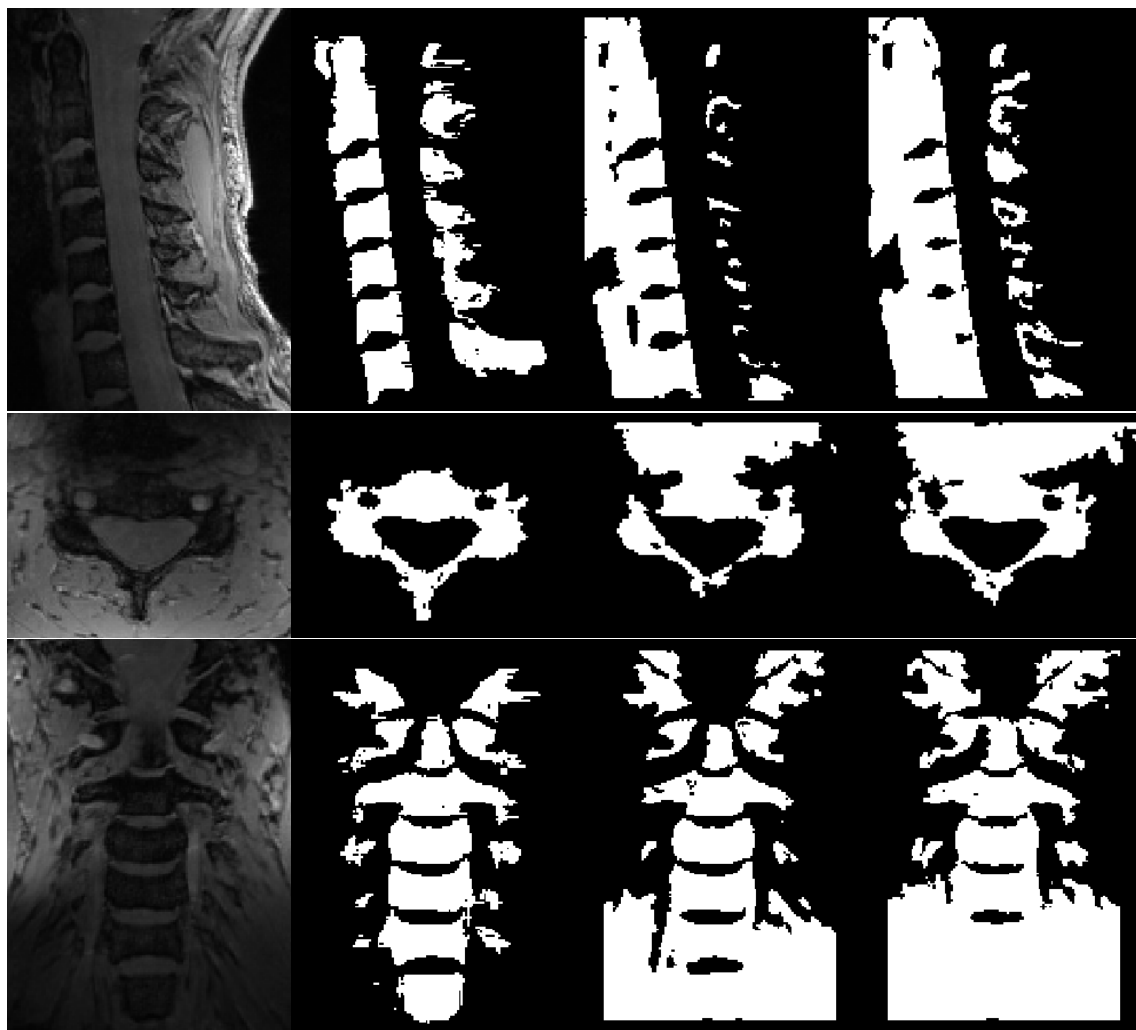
Comparison of the segmentations from the first subject. From left to right: a) MRI, b) manual segmentation, c) semi-automatic segmentation, and d) automatic segmentation. Top to bottom, the sagittal plane, the transverse plane and the coronal plane.
